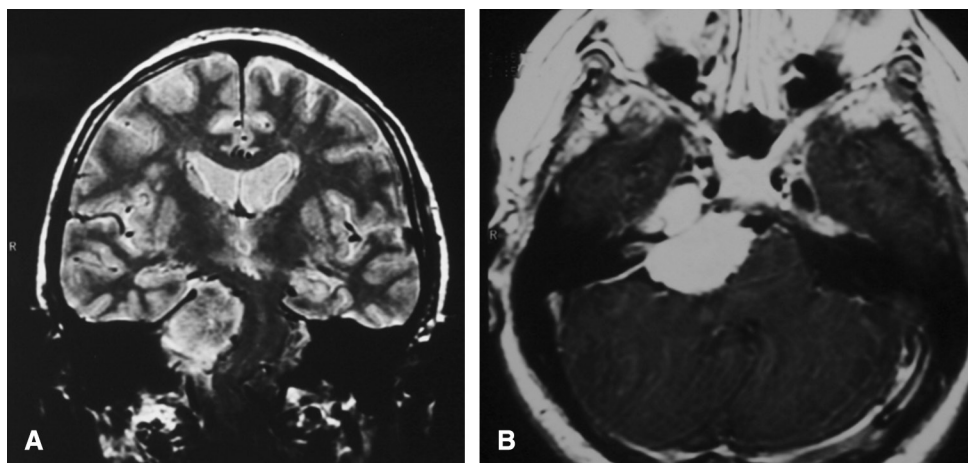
Preoperative MRI images. (A) Coronal T2-weighted magnetic resonance image and (B) axial T1-weighted image with gadolinium of a large right petroclival meningioma that completely occupies the cerebello-pontine cistern, protrudes upward through the tentorial incisura to the subtemporal subarachnoid space, invades the posterior portion of the cavernous sinus, obliterates the Meckel's Cavum, compresses and deviates the brainstem from right to left and compresses the aqueduct of Sylvius and the basilar artery. MRI: magnetic resonance imaging.
